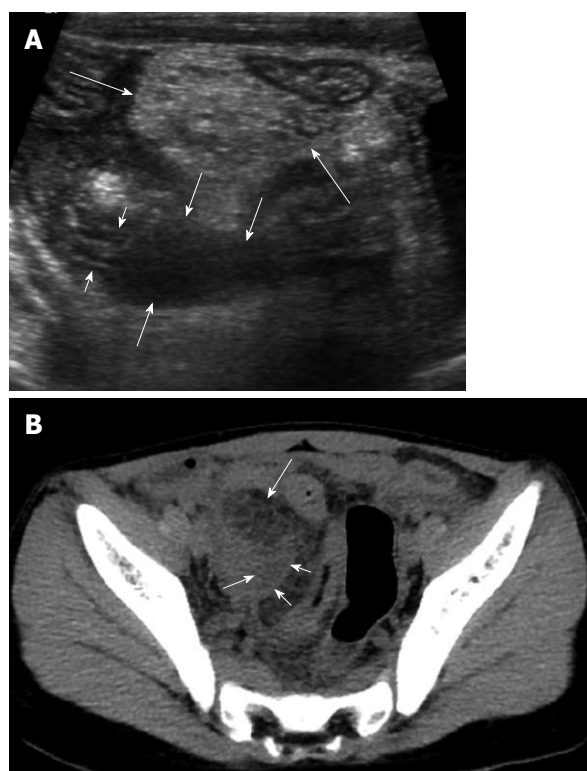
An 8-year-old male with perforated appendicitis. A: Initial US showed a collapsed appendix with distal wall defect (short arrows) and peri-appendiceal fluid collection (medium sized arrows) in the deep right lower abdomen. In addition, marked mesenteric inflammatory change (long arrows) was seen; B: Subsequent axial CT scan revealed loculated fluid (short arrows) corresponding to the periappendiceal fluid collection on US and marked mesenteric fat change (long arrow) in the right lower abdomen.
